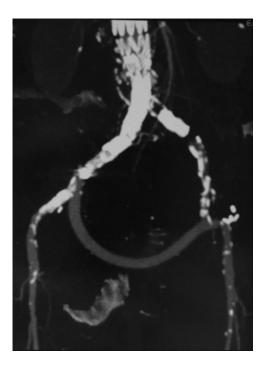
A computed tomography scan after completion of the anterior paramedian retroperitoneal approach shows an aortouniiliac stent graft with crossover ilioiliac bypass and reimplantation of the proximal external iliac artery.
